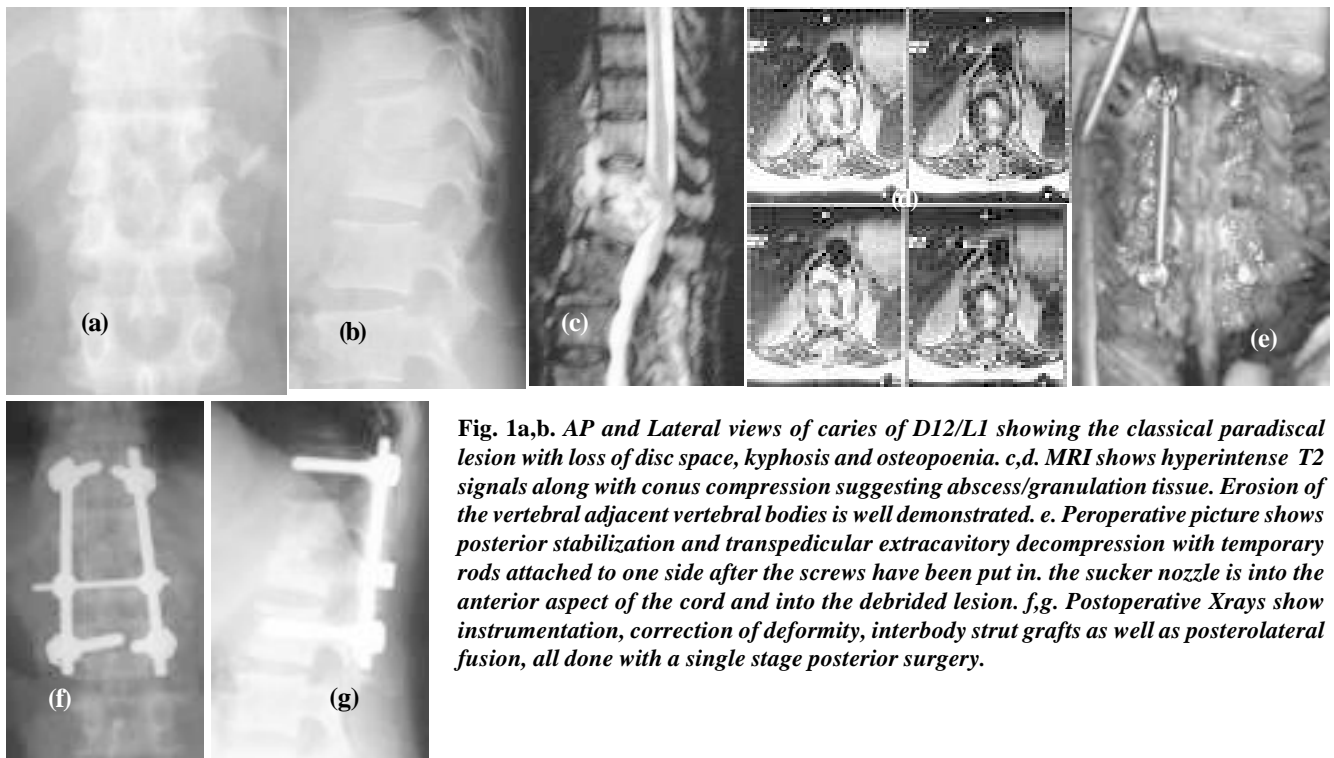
AP and Lateral views of caries of D12/L1 showing the classical paradiscal lesion with loss of disc space, kyphosis and osteopenia. c,d. MRI shows hyperintense T2 signals along with conus compression suggesting abscess/granulation tissue. Erosion of the vertebral adjacent vertebral bodies is well demonstrated. e. Peroperative picture shows posterior stabilization and transpedicular extracavitary decompression with temporary rods attached to one side after the screws have been put in. the sucker nozzle is into the anterior aspect of the cord and into the debrided lesion. f,g. Postoperative Xrays show instrumentation, correction of deformity, interbody strut grafts as well as posterolateral fusion, all done with a single stage posterior surgery.
